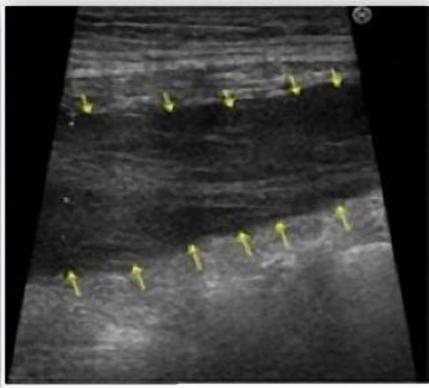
Hematoma in the left breast at breast ultrasound
